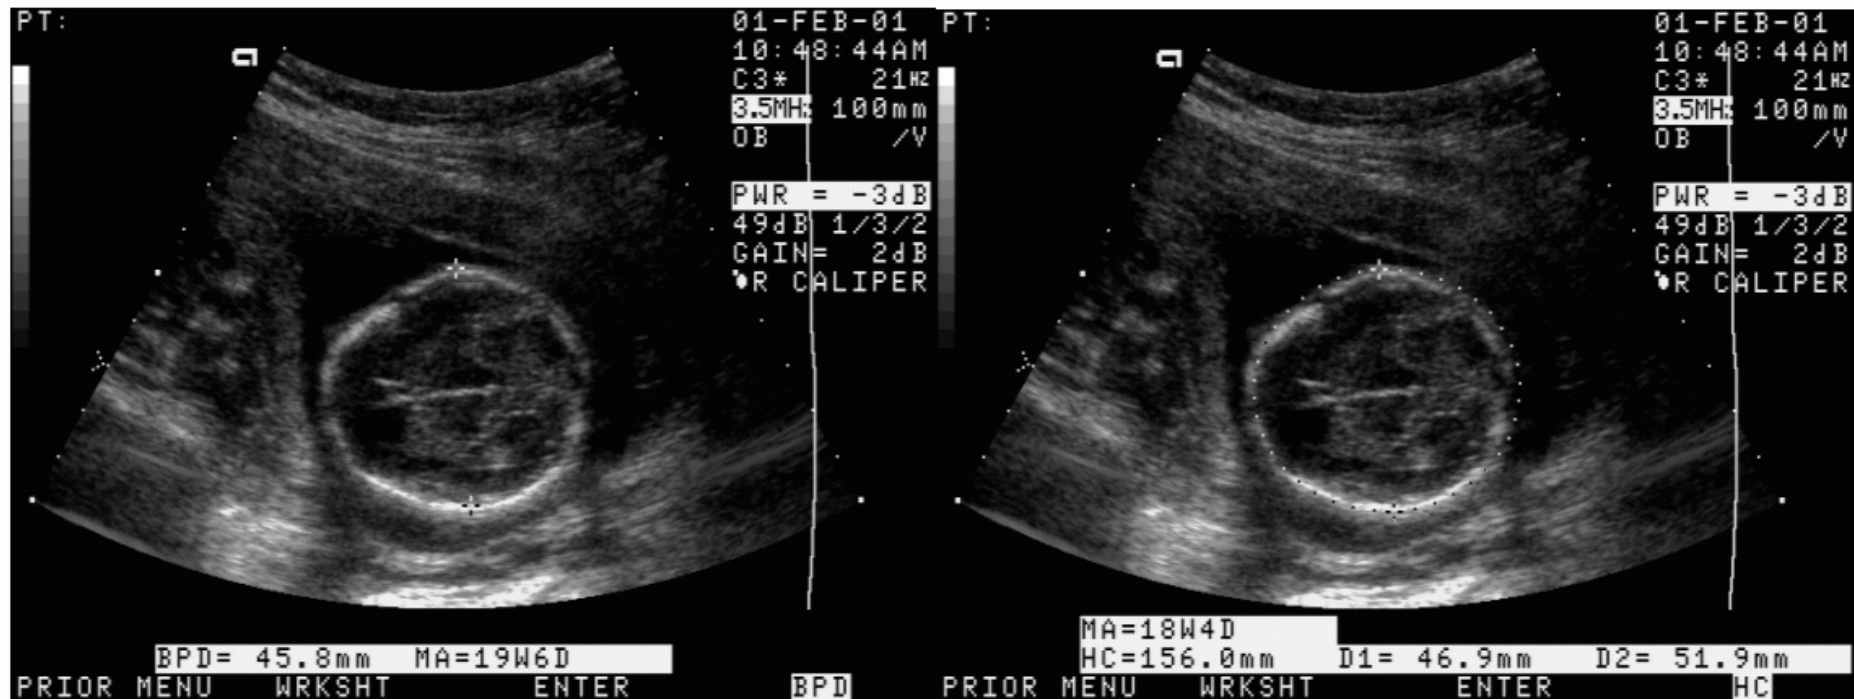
Ultrasound provides accurate distance measurements. Fetal age is often performed by biparietal (diameter) measurements (left) or circumference measurements (right). Based on known correlations, the age of the fetus in the image above is estimated to be 19 weeks and 6 days by the diameter assessment, and 18 weeks and 4 days by the circumference measurement.
